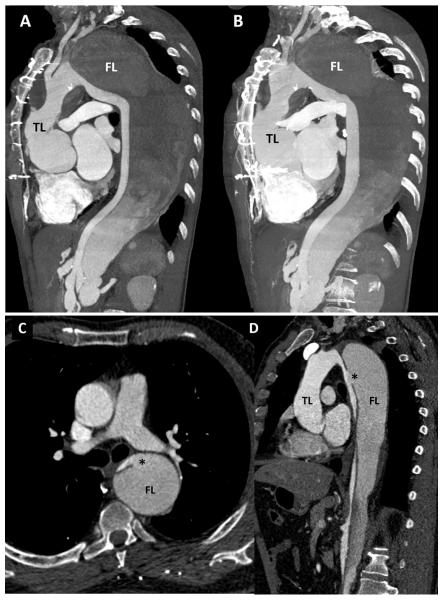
(above) Computed tomography 2D in a sagittal view in a patient with a residual type B aortic dissection (A) and MIP reconstruction (B). (below) Computed tomography 2D reconstruction in a patient with a type B aortic dissection. Image (C) showing an axial reconstruction at the level of the entry tear (*) and image (D) showing a sagittal oblique reconstruction of the aorta. Abbreviations: FL, false lumen; TL, true lumen.
